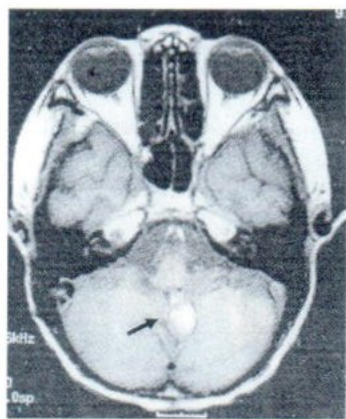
A MRI. T₁W₁ Axial projection
